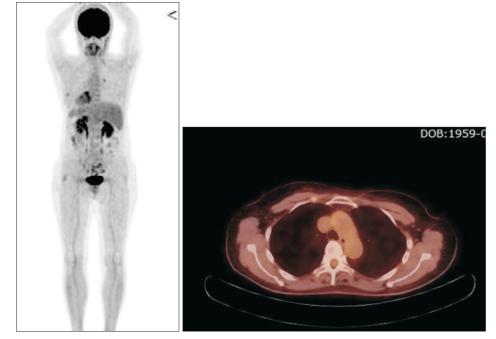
Positron emission tomographycomputed tomography. Hyeong-Geun Lee et al: Malignant lymphoma on parotid gland: a clinical case. J Korean Assoc Oral Maxillofac Surg 2017
